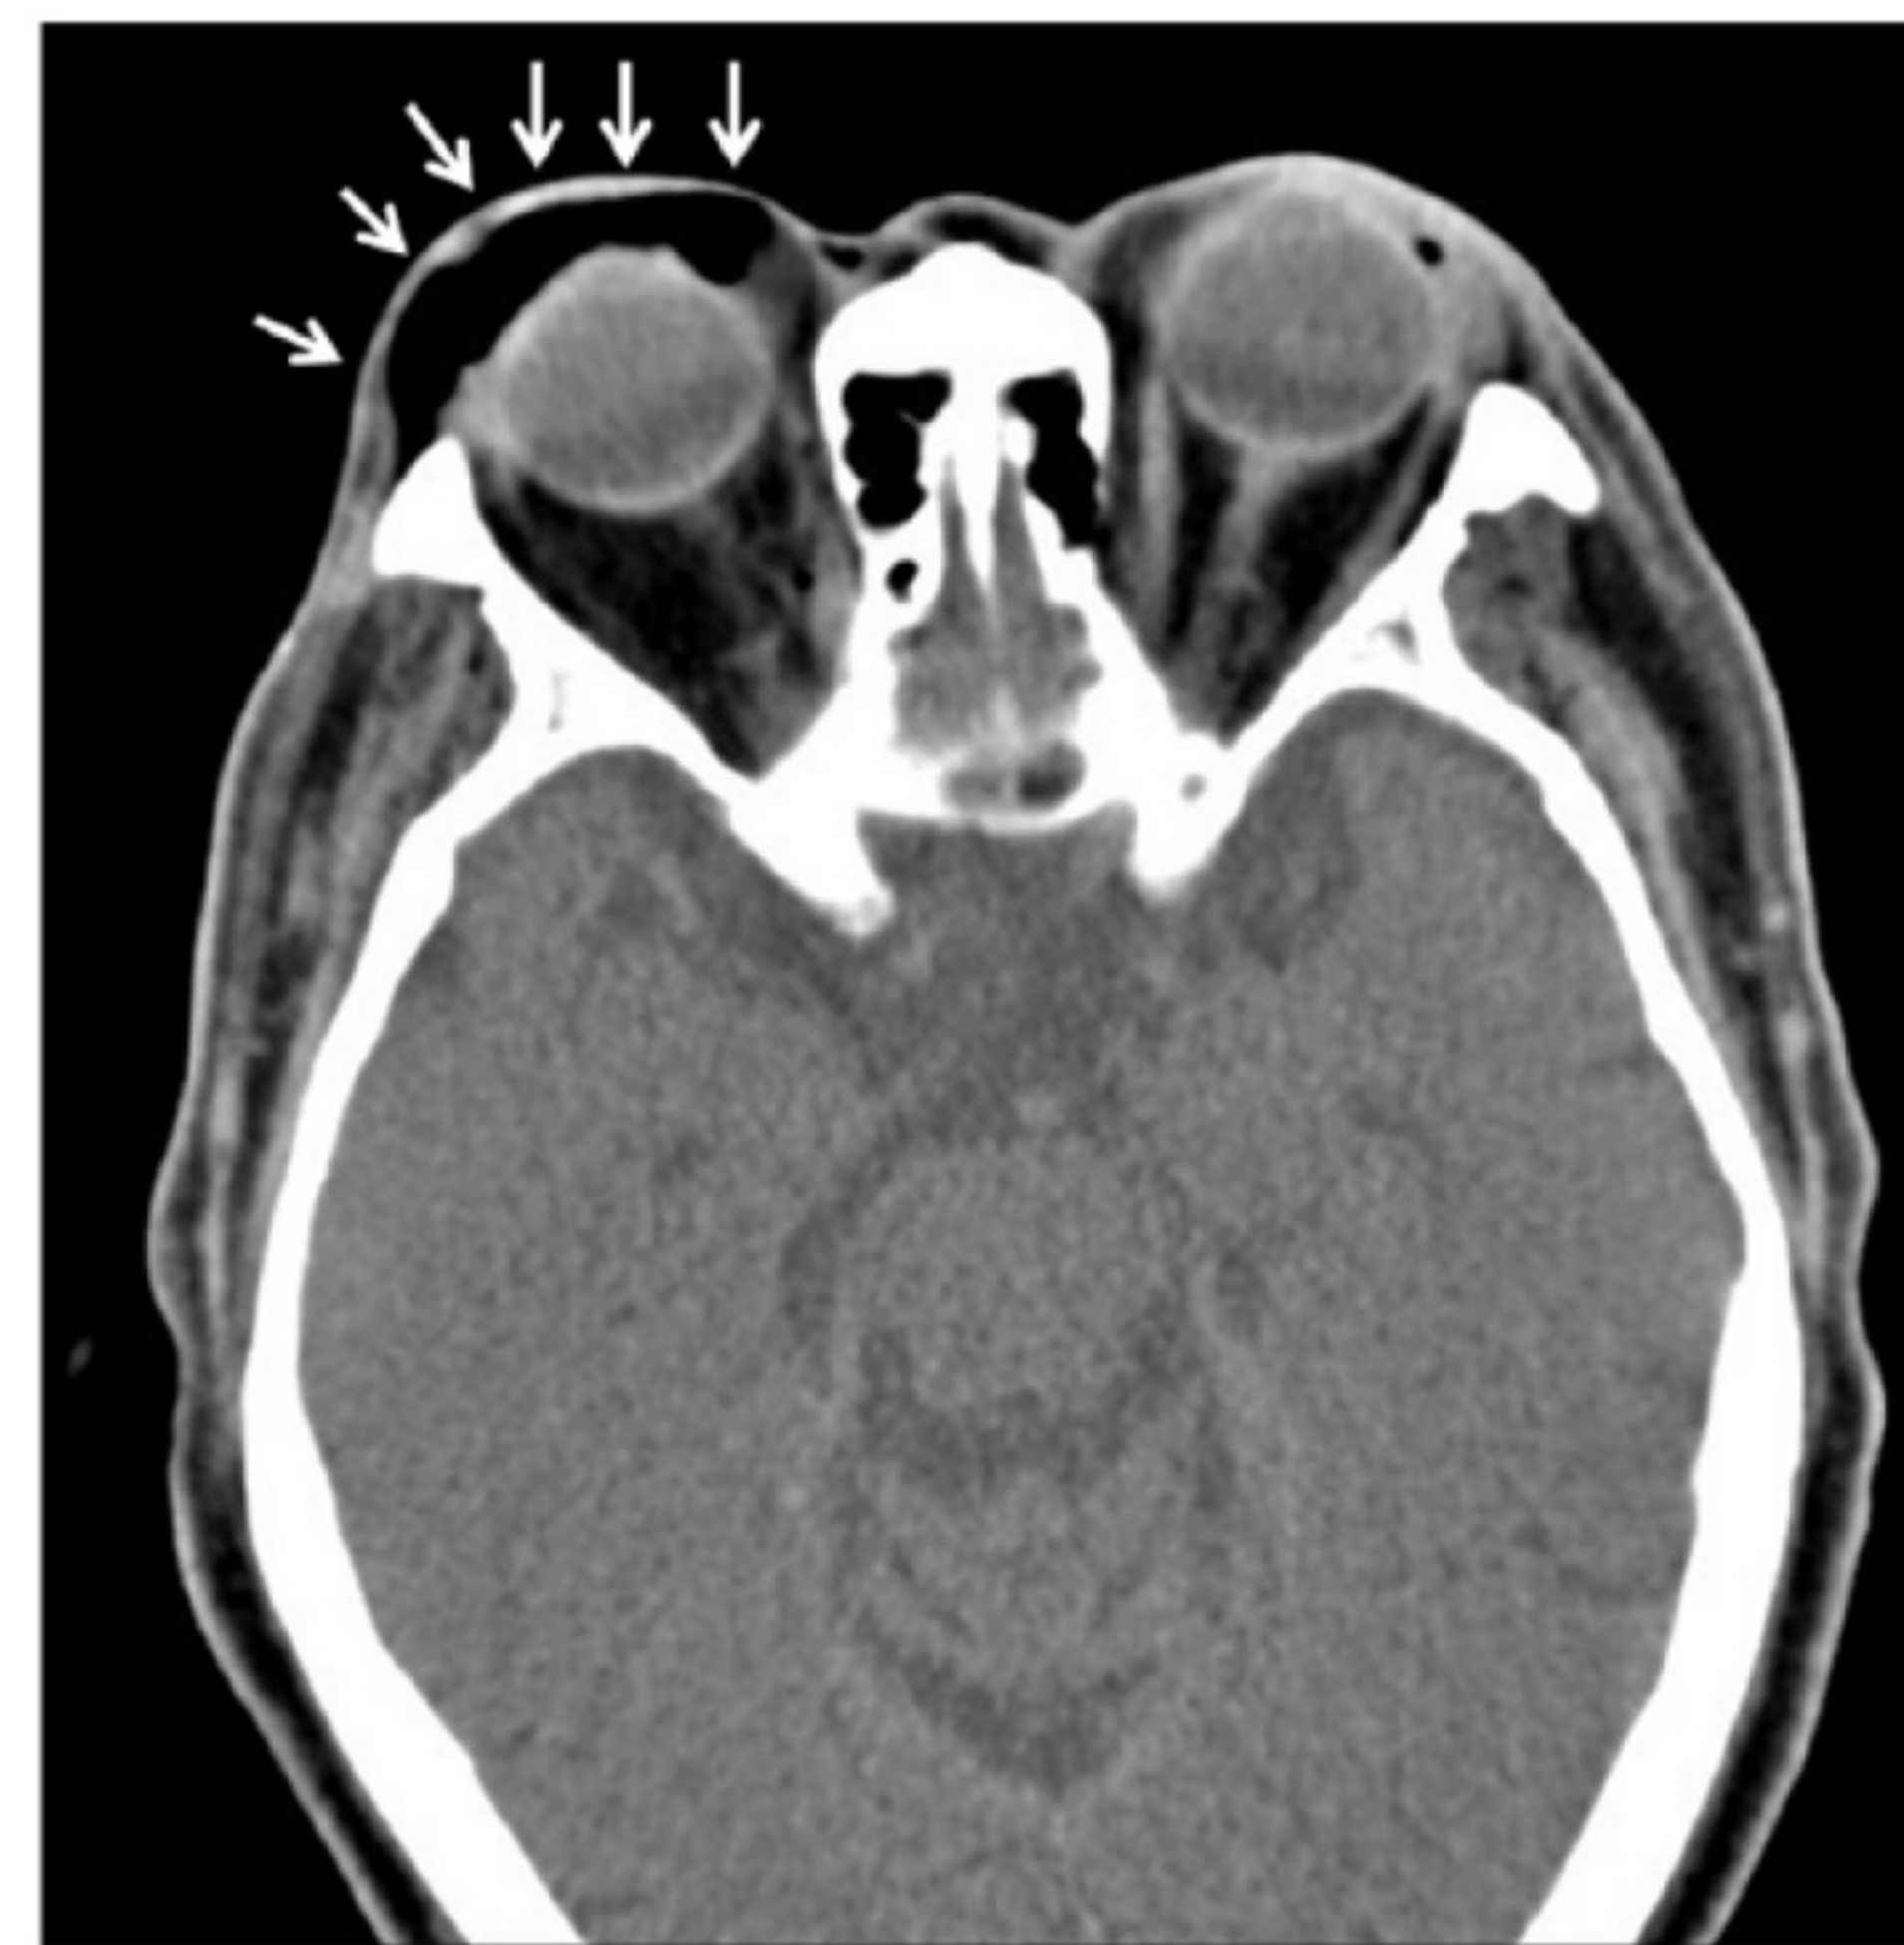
Coronal slice of a CT maxillary face in a soft tissue window width. Demonstrating subcutaneous emphysema surrounding right orbital cavity, periorbital cavity and infra temporal fossa. (Chan, Lio, Yu, Peng, & Chan, 2020, p. 177)
